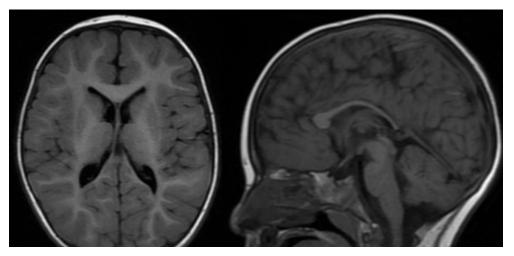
Patient 1 MRI T1 images showing hypoplastic corpus callosum and colpocephaly
